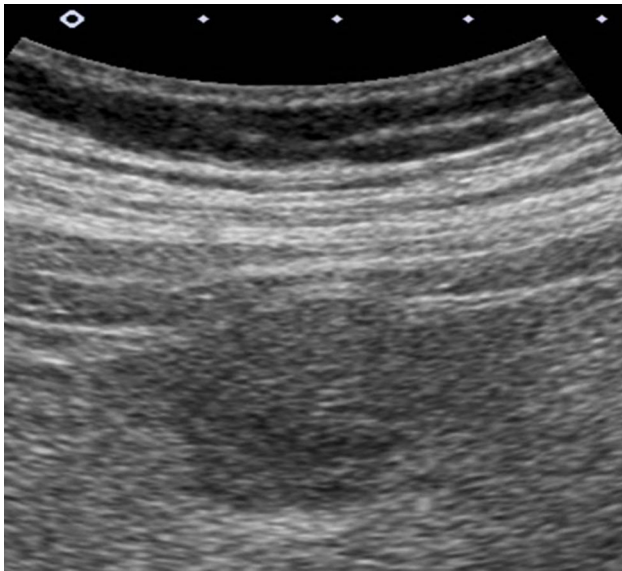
Ultrasound imaging showing an irregularly shaped, low-echoic mass measuring 21 × 18 mm in S6
